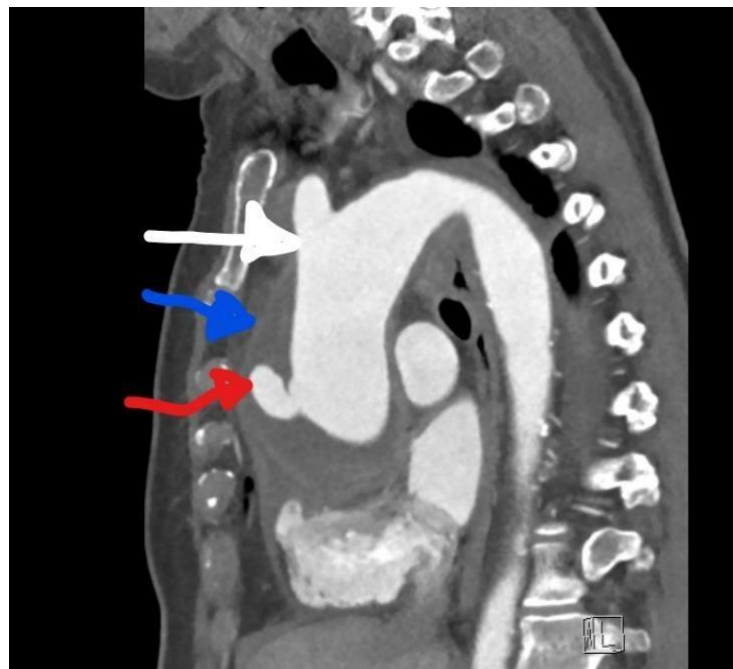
Reconstructed CT showing the proximal and distal extent of the IMH, white arrow points to the base of the innominate artery, blue arrow points to IMH and red arrow points to PAU
